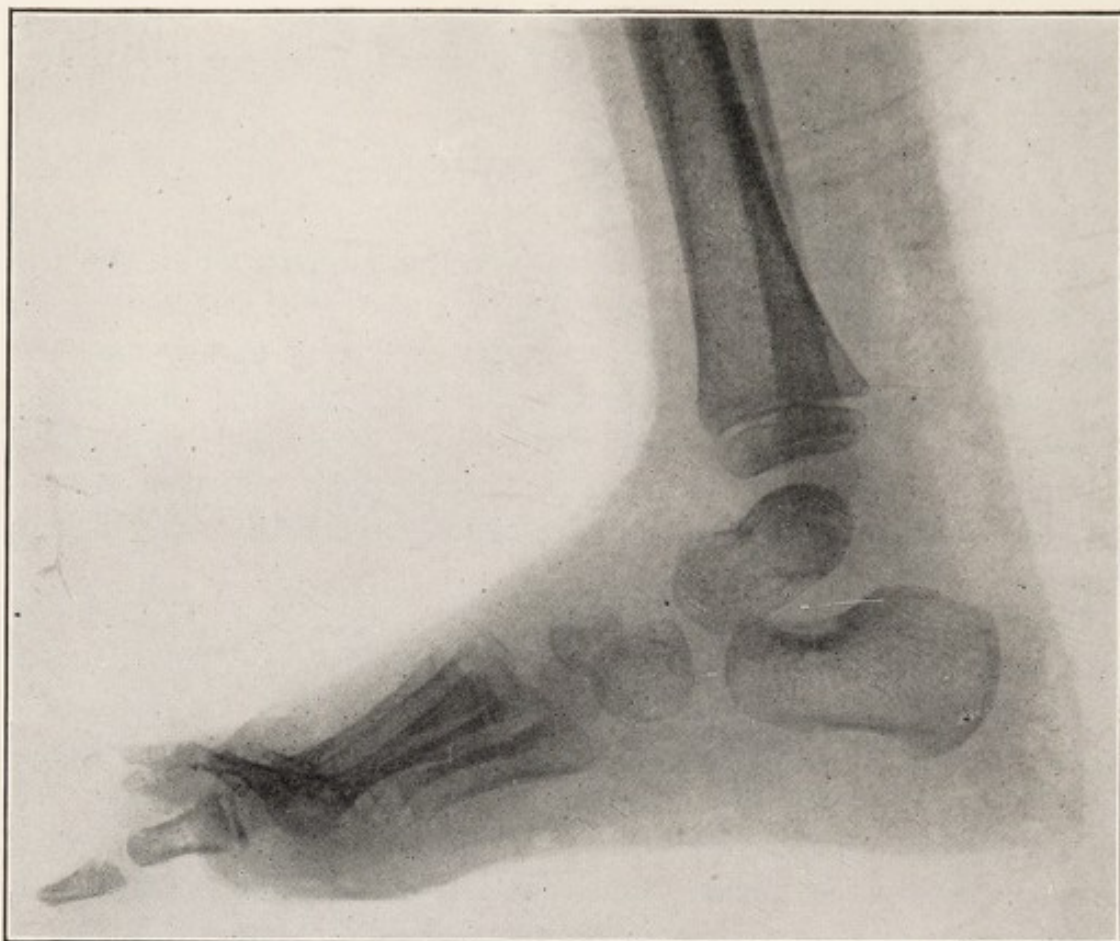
X-RAY OF NORMAL FOOT OF CHILD, AGE TWO YEARS, SHOWING THAT SCAPHOID AND EXTERNAL CUNEIFORM HAVE NOT APPEARED.
